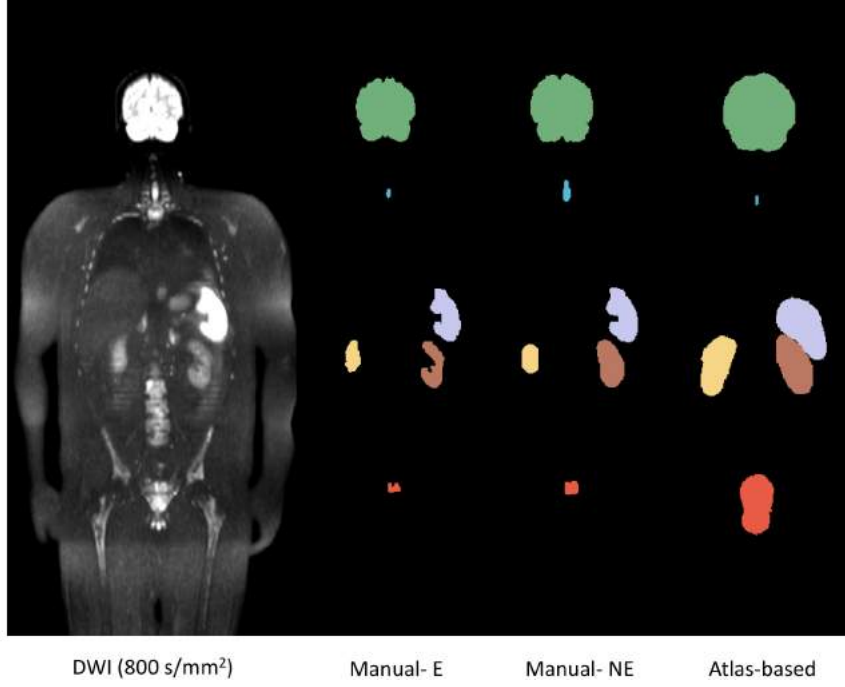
DWI representative coronal image, manual and automatic segmentation of hyperintense organs (brain- green, spinal medulla- blue, spleen- purple, left and right kidneys- brown and yellow, bladder- red and testis). One of the manual segmentation was performed by a radiologist (Expert- E) and the other was done by a researcher (Not-Expert NE). In this slice, the testis are not visible.
